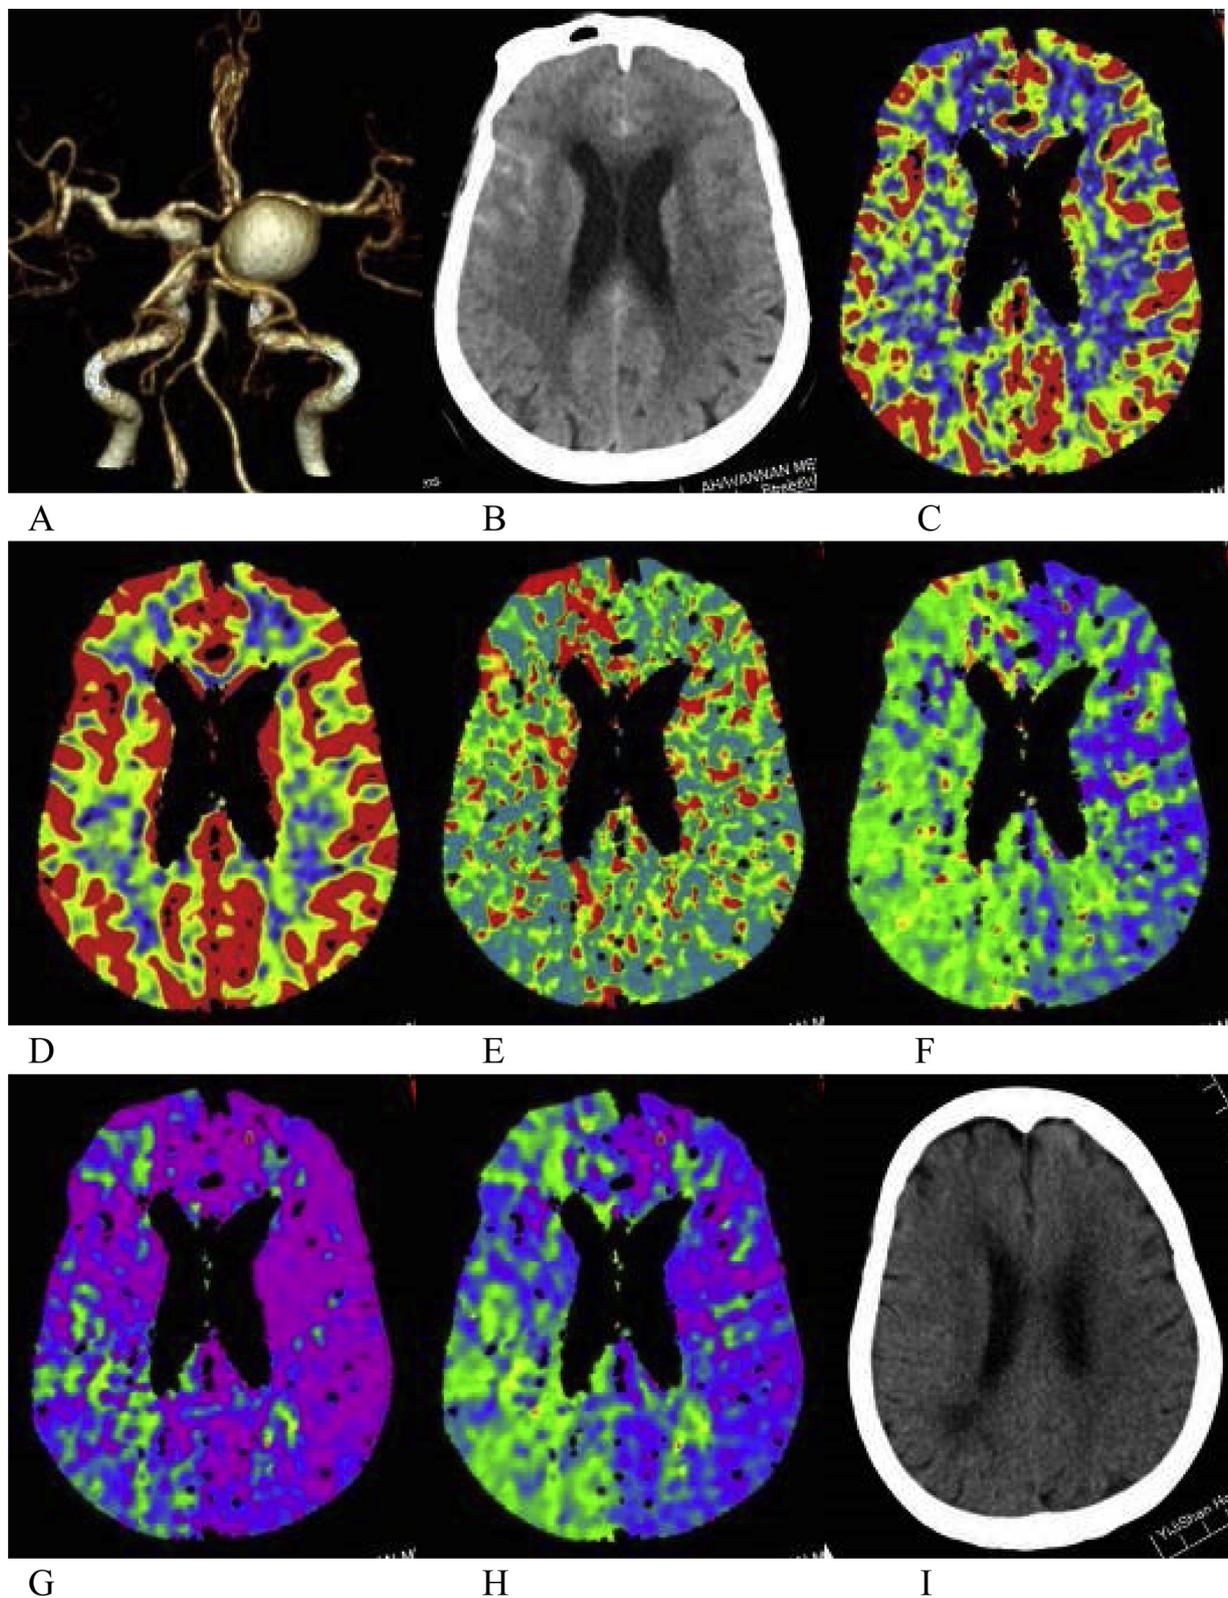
CTA (A) showed right posterior communicating aneurysm. The Fisher score was 2 on NCCT (B). Color-coded maps of CTP parameters (C–H) revealed that compared with the left hemisphere, the right hemisphere showed mild decreased CBF (C) and normal CBV (D), mild prolonged MTT (E), and significantly prolonged TTD (F), TTS (G), and TMax (H). Left hemiplegia occurred on day 18 after admission. There were multiple infarctions in the right hemisphere on follow-up CT (I).
